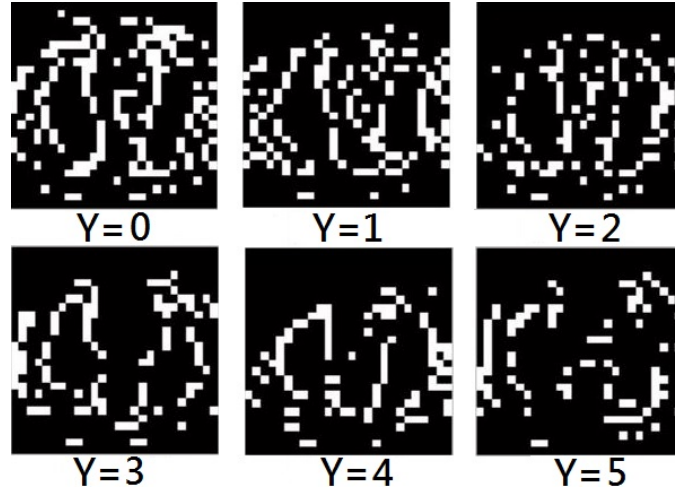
Thresholded 5th AFM images corresponding to the same CT slice from different image quality stacks. The thresholding pixel value=0.8. We observe that as the image quality improves ( $Y$  increases), the number of pixels in the thresholded image decreases. This observation is intuitive since low image quality induces large number of noisy false edges in the image.
